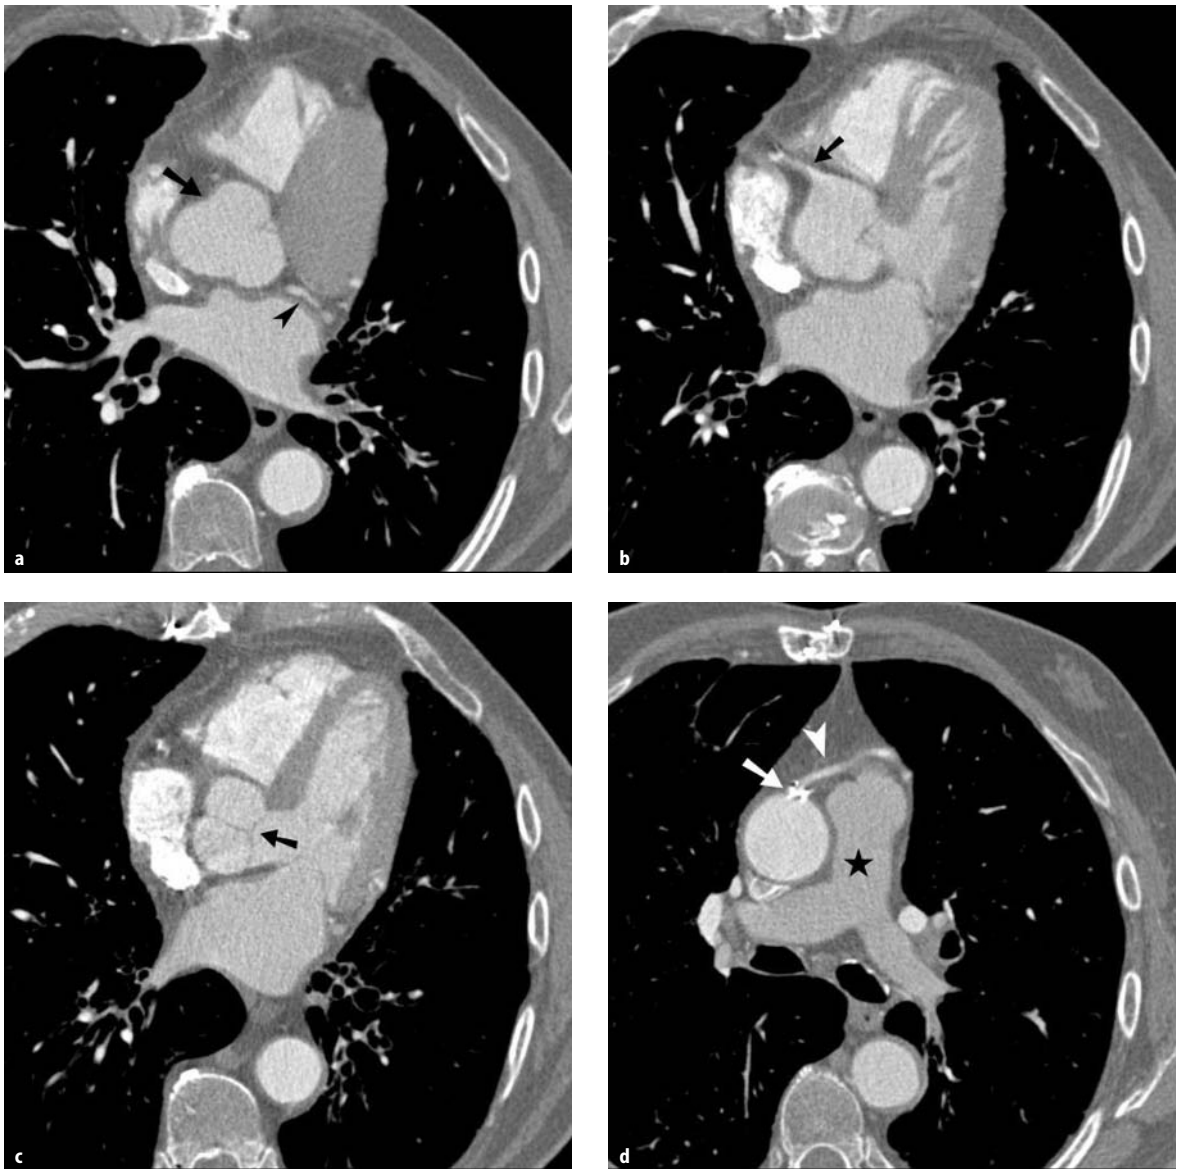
a Axial computerized tomography (CT) at the level of the aortic sinus (*arrow*). The trilobar appearance is clearly appreciated; part of the main stem of the left coronary artery is clearly seen (*arrowhead*). b Axial CT at a slightly lower level than in a demonstrating the origin of the right coronary artery (*arrow*). c Axial CT at a level below that in b depicting cusps of aortic valves (*arrow*). d Axial CT at the level of the common
